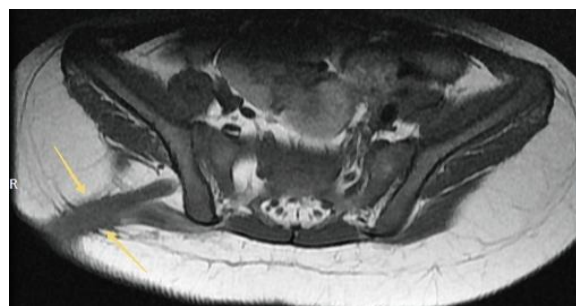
MRI showing a fistula extending from right lateral buttock to right pelvic cavity.
